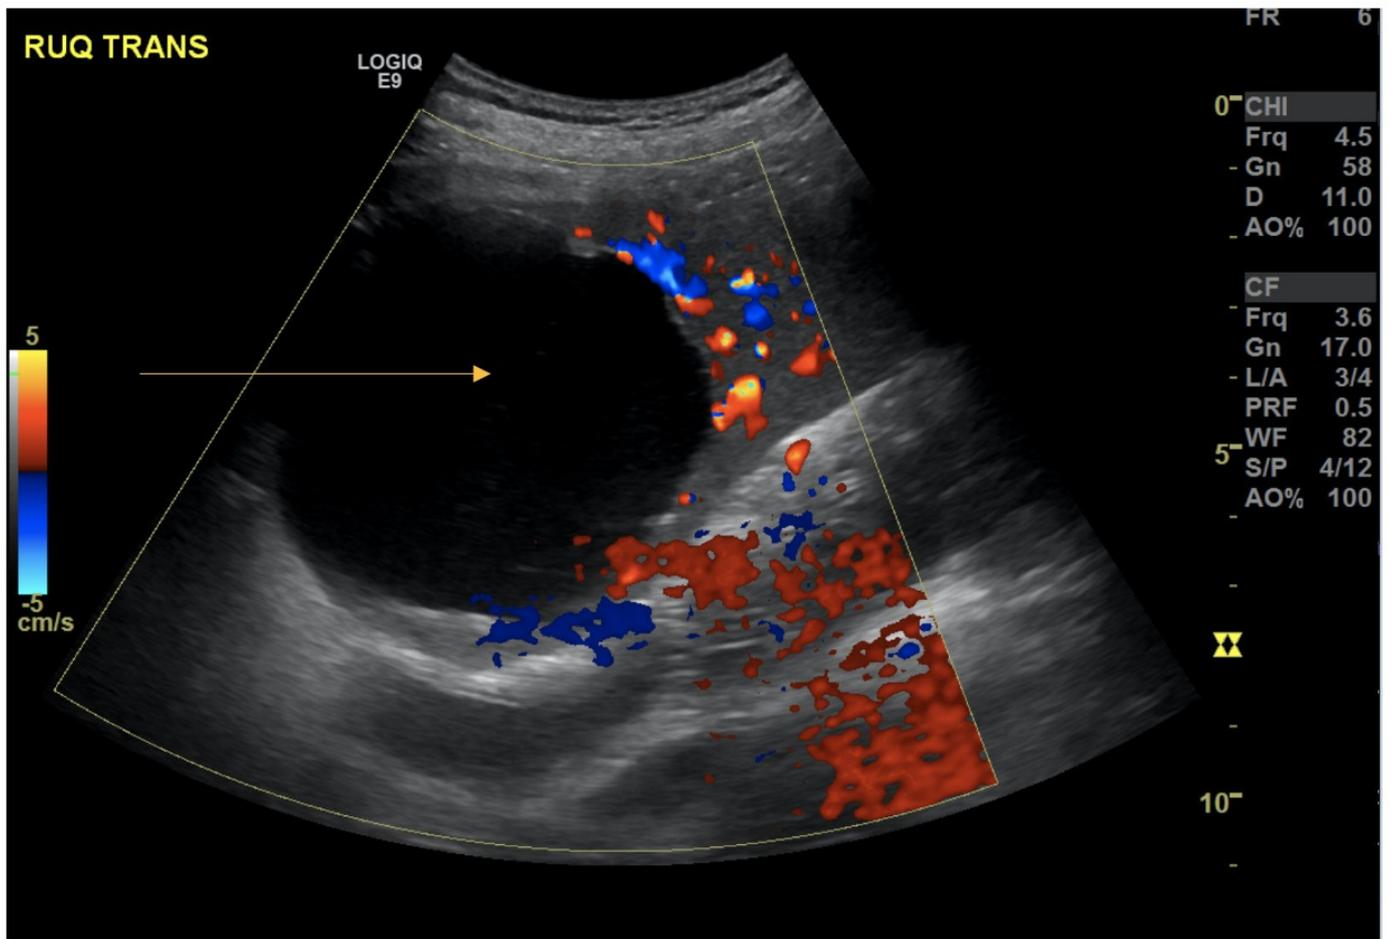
Follow up ultrasound shows stable splenic cyst with no internal color flow (yellow arrow).
